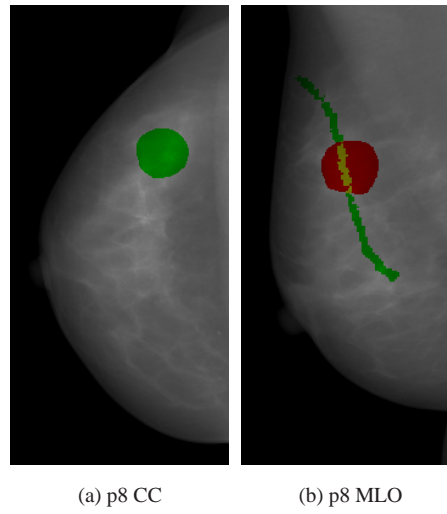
CC to MLO registration results for patient p8. The X-ray annotation of the CC view and its projection on the MLO are shown in green. The X-ray annotation on the MLO view is shown in red. The error is $0.2mm$.
